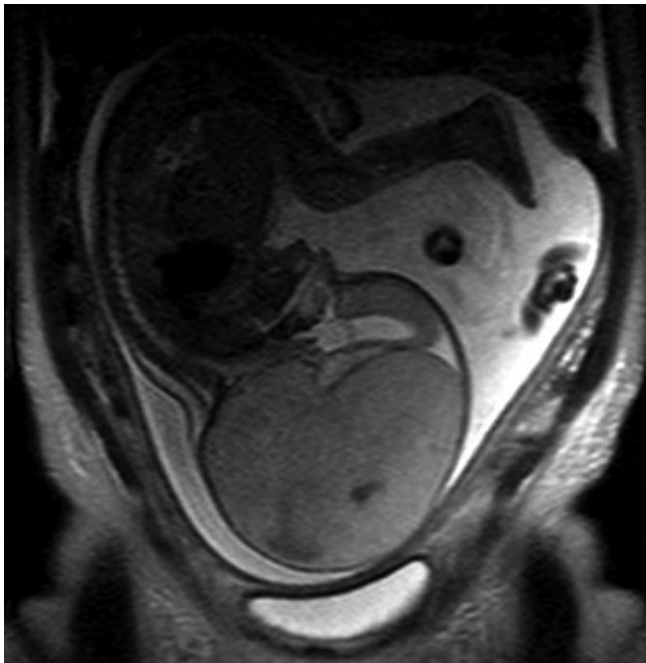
Prenatal MRI. Note size of head relative to body.
